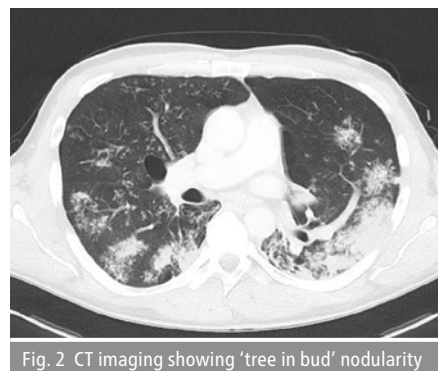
CT imaging showing 'tree in bud' nodularity
